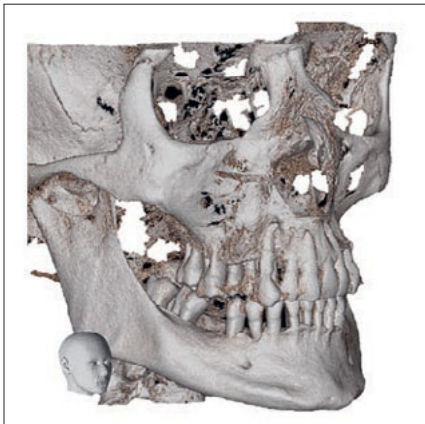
3D reconstruction from CBCT in a patient with advanced attachment loss. The situation of each tooth can be individual; thus, anchorage quality and the force level required vary.
